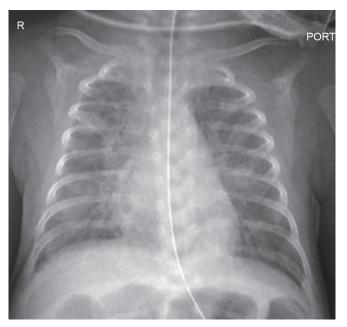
Chest X-ray of case 2 showing bilateral granular opacities
